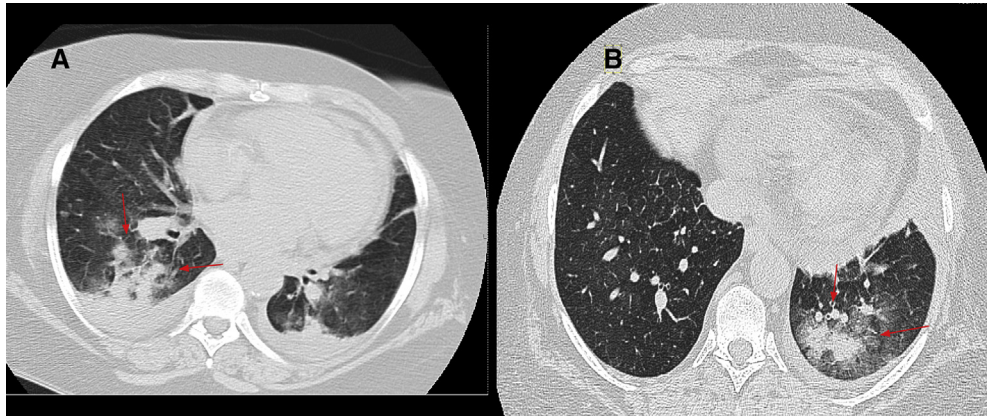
(A, B) Axial computed tomography on lung windows (kilovoltage peak: 120 milliamperes: 158). Patient is a 60-year-old female with history of renal transplant and worsening dyspnea. Interstitial lung disease was suspected and high-resolution computed tomography was performed. An axial slice on lung windows shows peribronchovascular opacities with subpleural sparing, and peripheral ground-glass opacities or the reverse halo sign (red arrows). Incidental note is made of small bilateral right greater than left pleural effusions. The focal opacities resolved once additional immunosuppression was administered, however, there were residual ground-glass opacities resembling nonspecific interstitial pneumonia, and a biopsy was performed.
